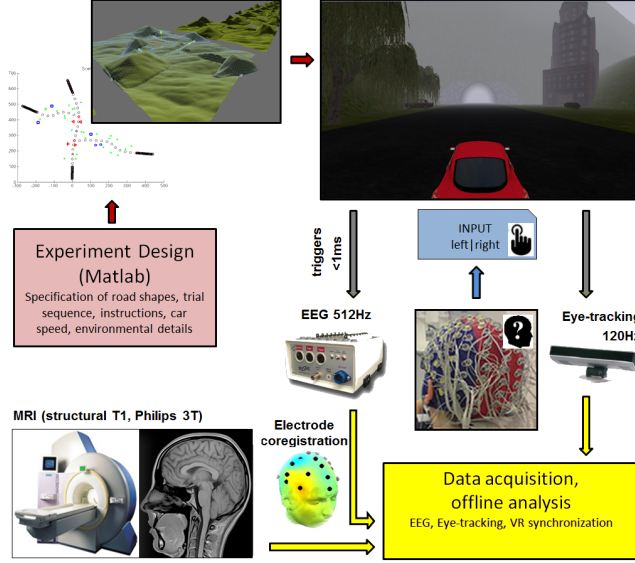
Virtual Reality (VR) design and synchronization with multi-modal data. A set of Matlab scripts specifies experimental design, i.e. sequence and timing of trials, shape of roads, position of crossroads, etc (top left). For each block of experiment, one Unity3D game is compiled, based on the specified experimental design (top right). During the cognitive experiment, fast encephalographic data from participants scalp and eye-tracking data are acquired (mid-right), which are synchronized with the game events by hardware triggering. Prior to the main experiment, structural MR images of participant brain are recorded with Philips 3T scanner (bottom left). EEG signals can then be coregistered offline with structural MR images by means of 3D electrode position measurements (Localite Neuro-Navigation system).
